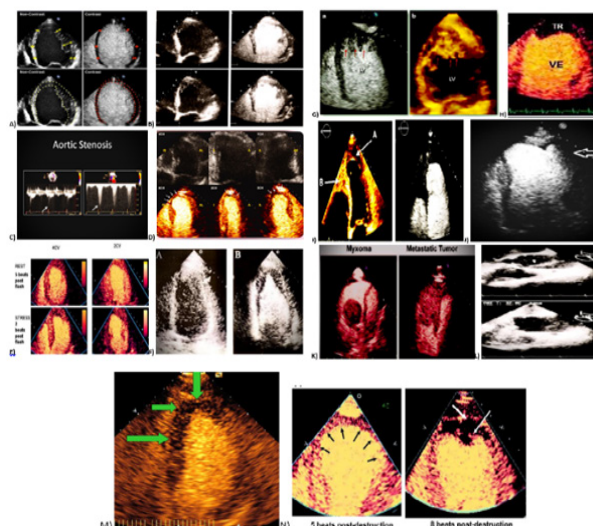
A) LV border definition. Left panel unenhanced image, Right panel enhanced image in a patient of dilated cardiomyopathy. B) Estimation of LV volumes and ejection fraction. C), Continuous wave doppler image enhancement of a patient with severe Aortic stenosis. D), Identification of segmental wall motion analysis at rest, by Transthoracic myocardial contrast Echocardiography. E), Identification of LV segmentation wall motion analysis after stress, consistent with multi-vessel coronary artery disease. F), Detection of Apical Hypertrophic Cardiomyopathy. G) Detection of Non-Compaction Cardiomyopathy. Left panel showing deep recesses (red arrows), Right panel is 3D reconstruction of the same image. H), Delineation of LV apical thrombus. I), Detection of Eosinophilic Cardiomyopathy. J), Depiction of LV pseudoaneurysm. K), Detection of LV non- thrombotic masses- myxoma and metastatic tumor. L), Depiction of Aortic dissection flap, true and false lumen. M), Myocardial contrast echocardiography. N), Myocardial contrast perfusion Echocardiography in a patient of apical myocardial infarction.
